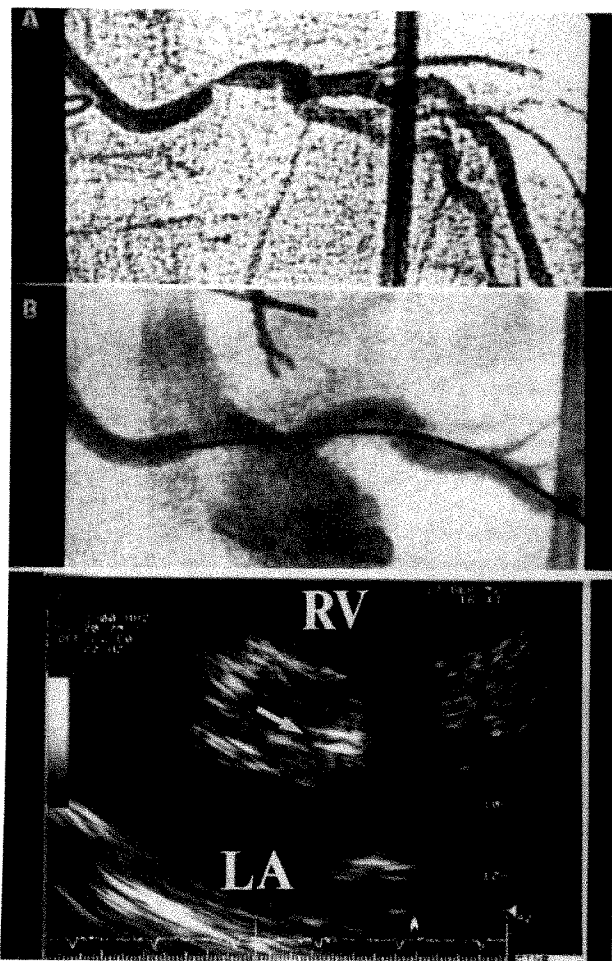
A, critical ostial lesion of the left main coronary artery from the right anterior (10°) oblique projection. B, left anterior oblique (20°) projection showing an optimal angiographic result after stenting. Note how contrast flushing is performed with the guidewire in place after nonselective engagement of the ostium with the guiding catheter to avoid stent damage. Bottom, echocardiographic study from the parasternal short-axis view revealing the stent (arrow) slightly protruding into the aortic lumen. LA = left atrium; RV = right ventricular outflow tract.
